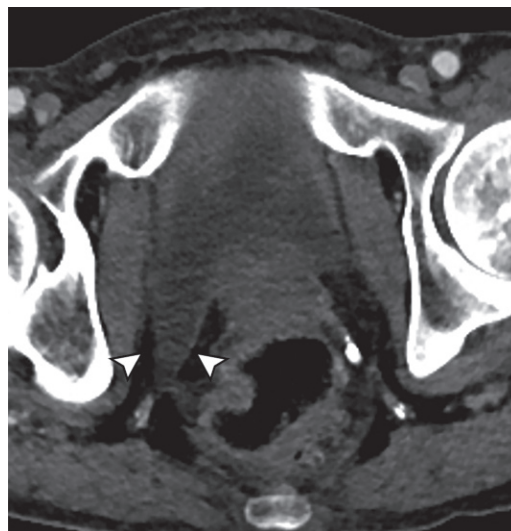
The saddle bag sign in a 53-year-old man. Axial contrast-enhanced CT image of the pelvis shows drooping of the right bladder wall posteriorly (arrowheads), which may be secondary to deficiency of the Denonvillier fascia.
